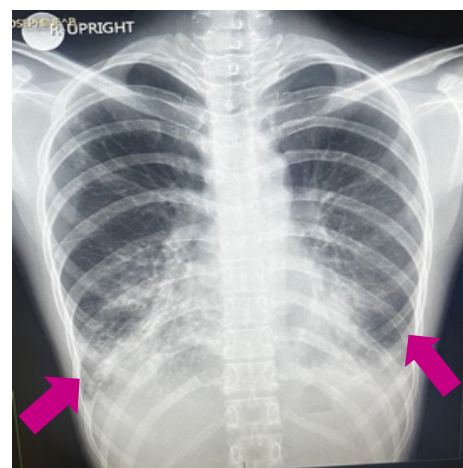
Chest radiograph of a 16-year-old female presenting with cough, hemoptysis, fever, and weight loss, taken on the day of admission (arrows: bilateral pleural effusion vs thickening)
